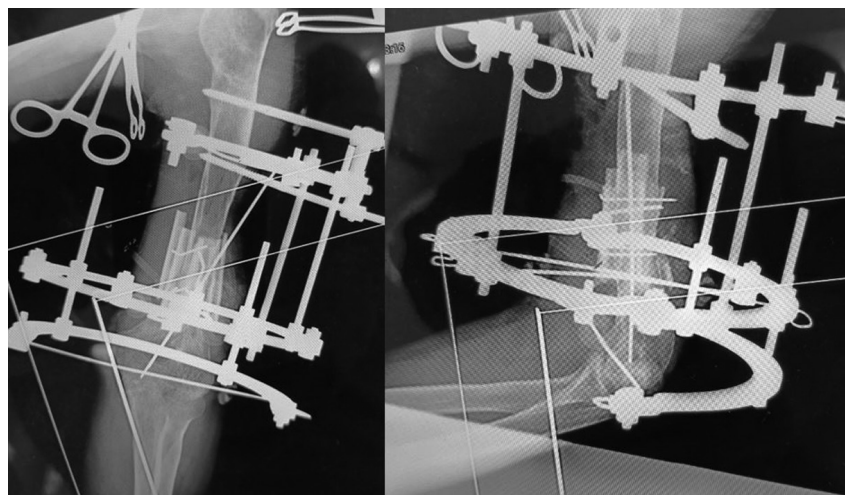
Intraoperative radiographs of the left humerus in two projections taken on 26.04.2024
